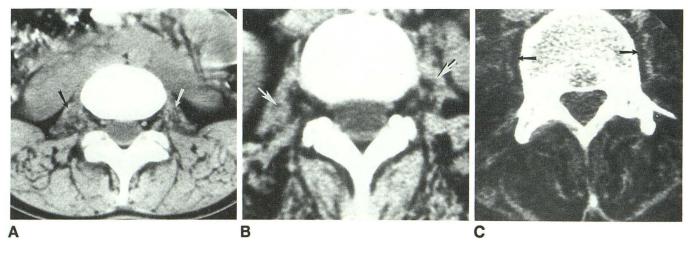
CT scans in patients with acid maltase deficiency.
